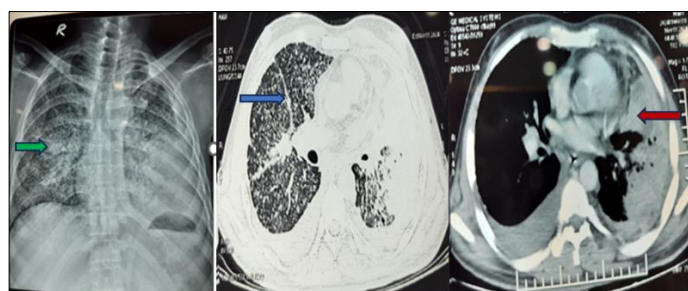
Chest Xray showing multiple miliary nodules (green arrow): 1B- CT Thorax- Perilymphatic nodules suggestive of lymphangitis carcinomatosa (blue arrow): 1C-CT showing left upper lobe mass (red arrow)
